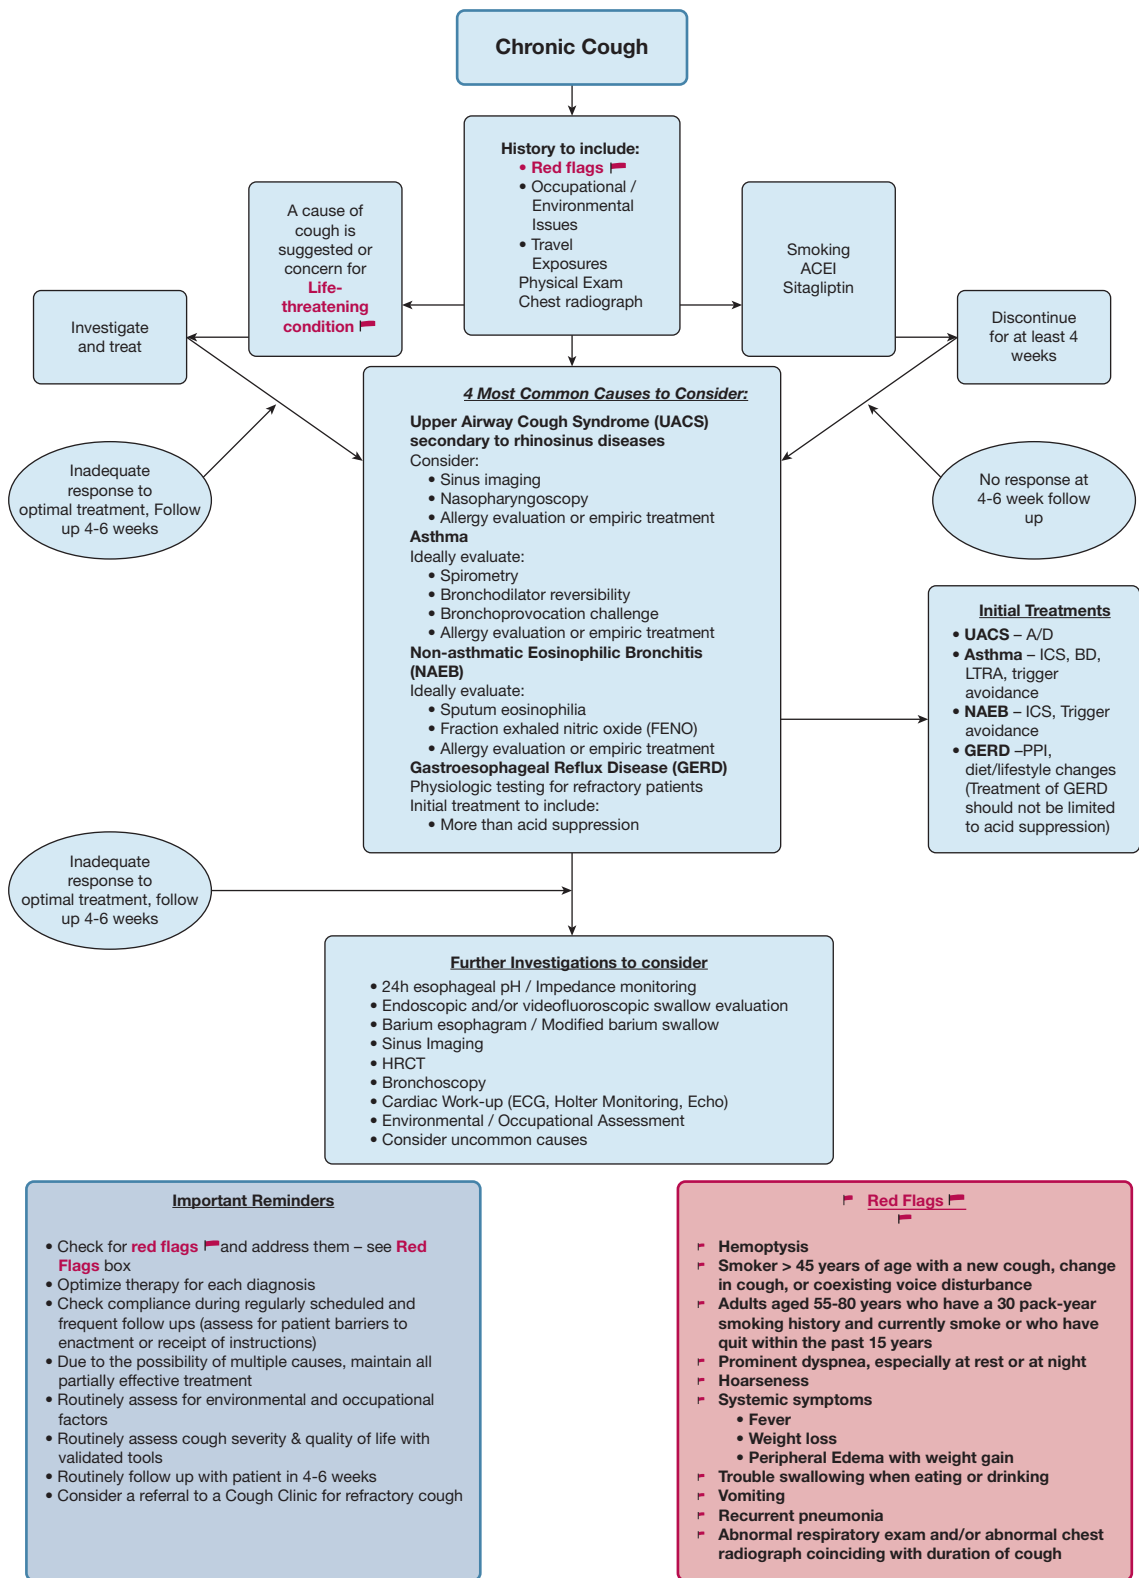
Chronic cough algorithm for the management of patients ≥ 15 years of age with cough lasting > 8 weeks. Always screen for red flags as a clue to a potentially life-threatening condition, as well as historical clues for environmental and occupational factors that might be contributing to the cough. Always evaluate whether sitagliptin as well as angiotensin-converting enzyme inhibitors are contributing to the patient's cough. Always consider the presence of TB in endemic areas or high-risk populations even if chest radiographs are normal. Be aware that treatment of cough due to GERD should not be limited to acid suppression. Remember to routinely assess cough severity or quality of life before and after treatment and routinely follow patients 4 to 6 weeks after the initial visit. Consider referral to a recognized cough clinic for patients with refractory unexplained chronic cough. ACEI = angiotensin-converting enzyme inhibitor; A/D = antihistamine/decongestant; BD = bronchodilator; HRCT = high-resolution CT; ICS = inhaled corticosteroid; LTRA = leukotriene antagonist; PPI = proton pump inhibitor. See Figure 3 and 4 legends for expansion of other abbreviations.
